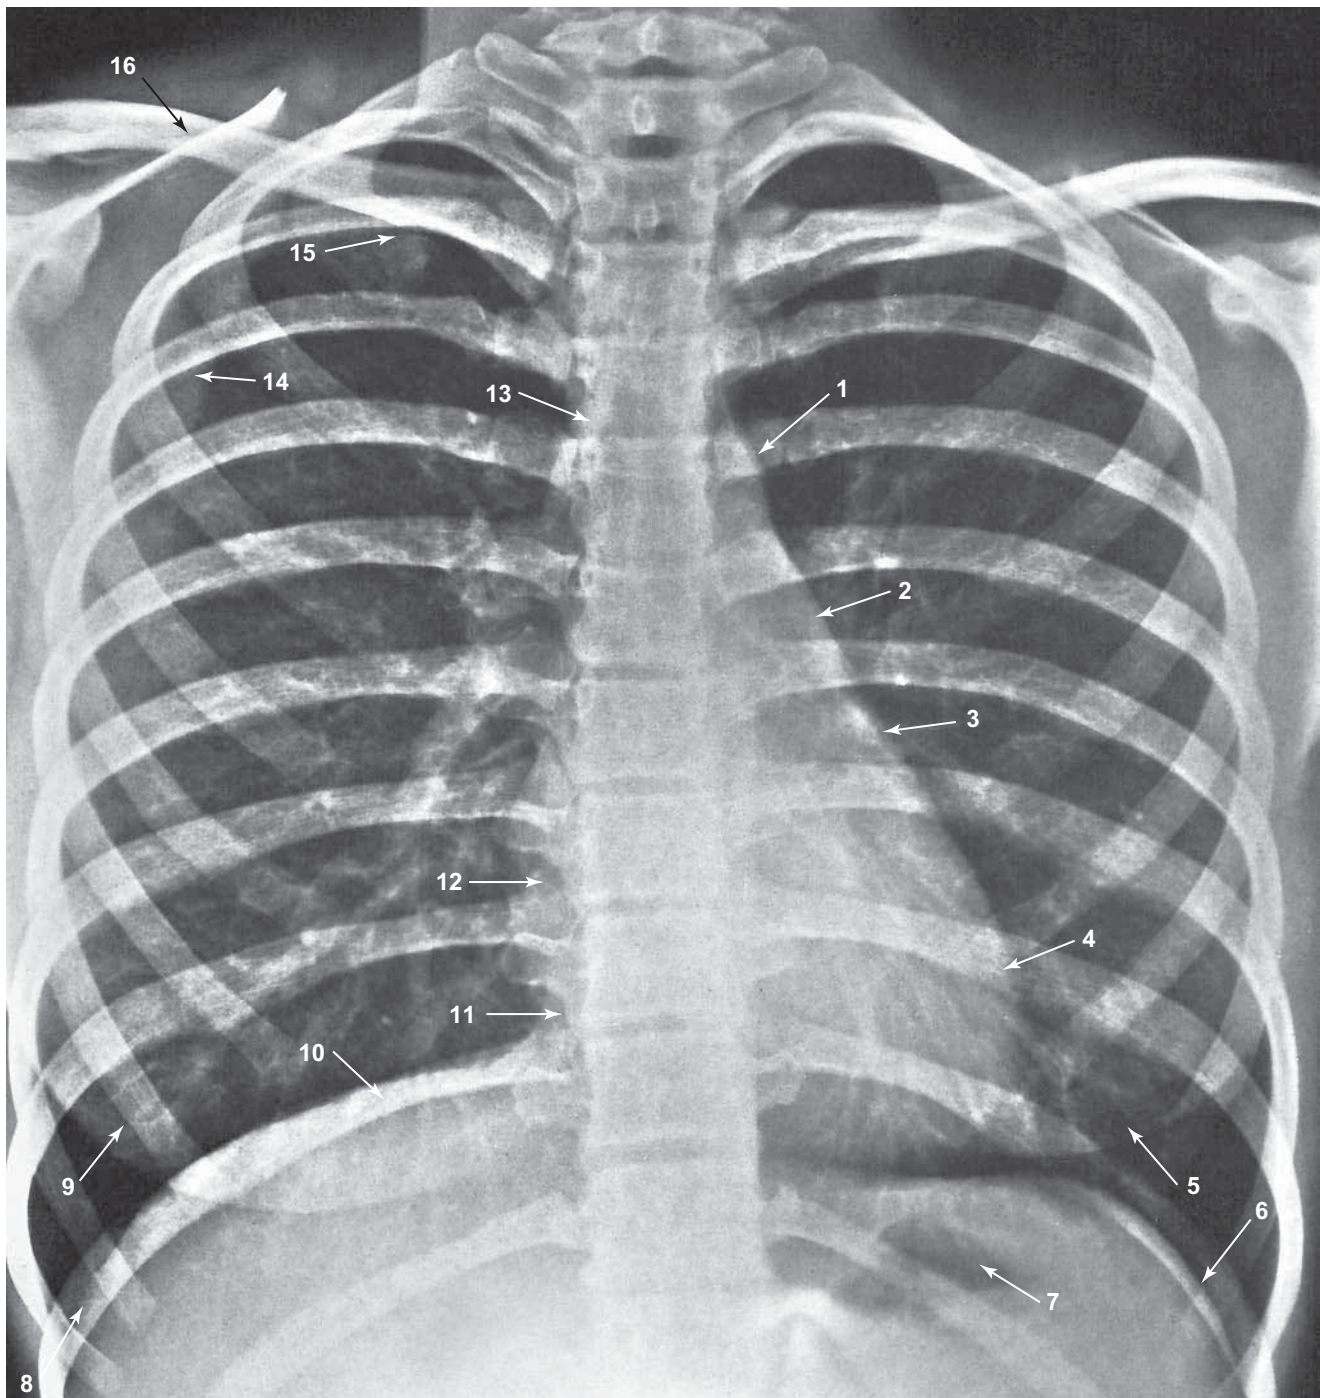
Posteroanterior Radiograph of the Thorax Showing the Heart and Lungs
